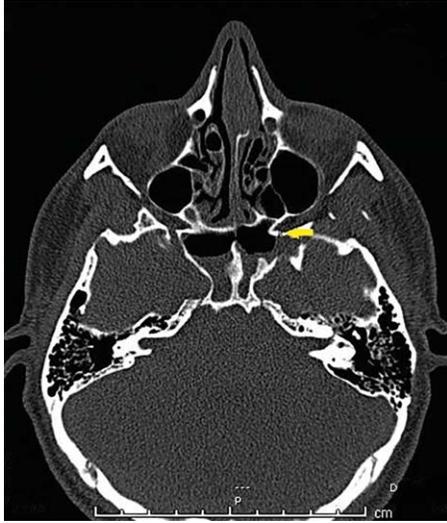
A 3.6 mm defect in the lateral recess of the sphenoid sinus is shown in the axial section PNS CT of patient 2.
